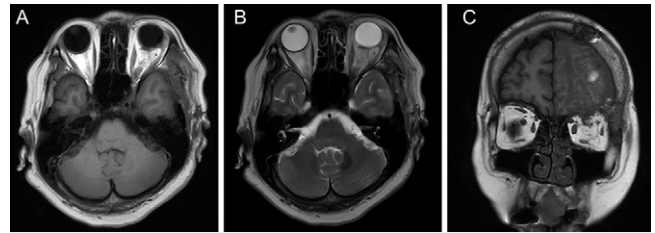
Postoperative axial T1- (A) and T2-weighted (B) and coronal T1-weighted (C) MRI showing removal of the tumor.
